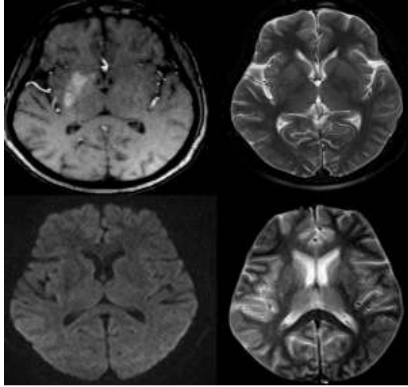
(a-d): MRI sections of the brain show T1 hyperintense signal in the left caudate nucleus with no associated corresponding abnormality in T2-weighted, diffusion weighted and T2 weighted gradient sequences
